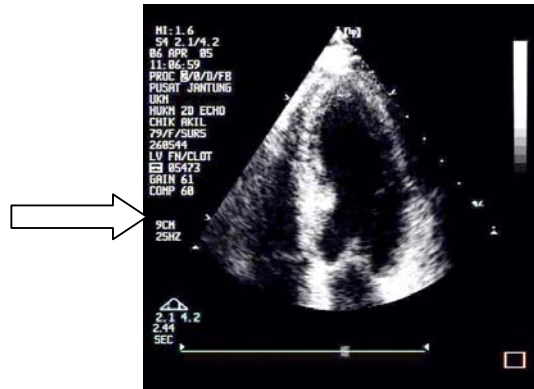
(b):Echocardiography image, atypical ultrasound image of human heart.
